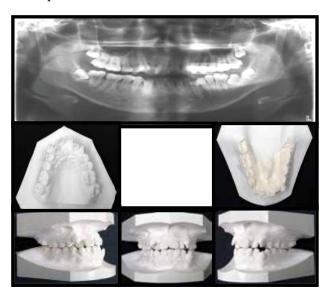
Pre-treatment orthodontic radiographs and dental model photographs.
